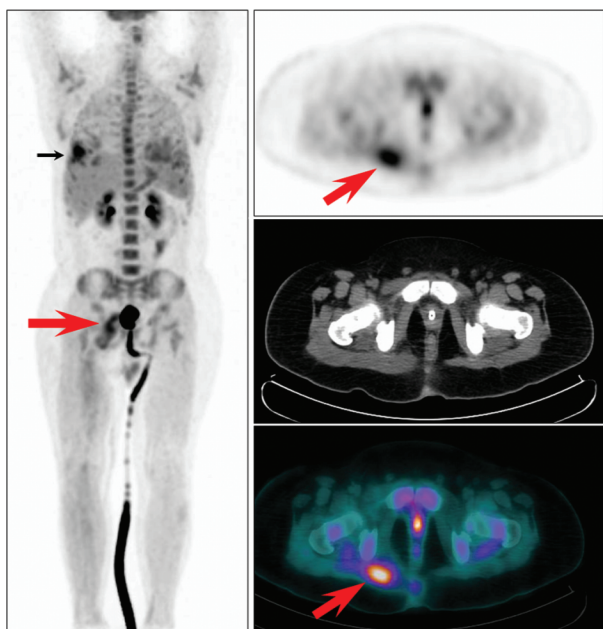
FDG PET-CT findings in a patient with fever of unknown origin. The investigation revealed an unsuspected abscess in the right gluteus muscle (large arrows red) and a second FDG-avid focus in the right lung (small black arrow).
